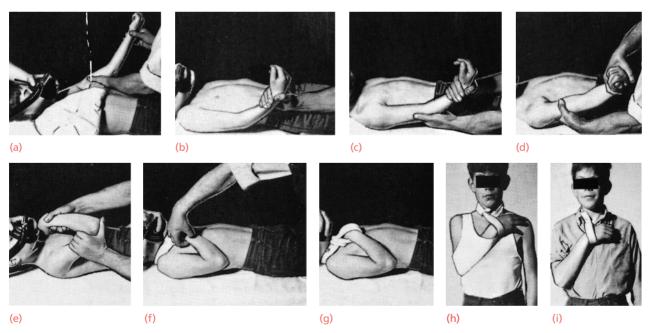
Supracondylar fractures – treatment (a) The uninjured arm is examined first; (b) traction of the fractured arm; (c) correcting lateral shift and tilt; (d) correcting rotation; (e) correcting backward shift and tilt; (f) feeling the pulse; the elbow is kept well flexed while X-ray films are taken (g). (h) For the first 3 weeks the arm is kept under the clothes; after this (i) it is outside the clothes.
